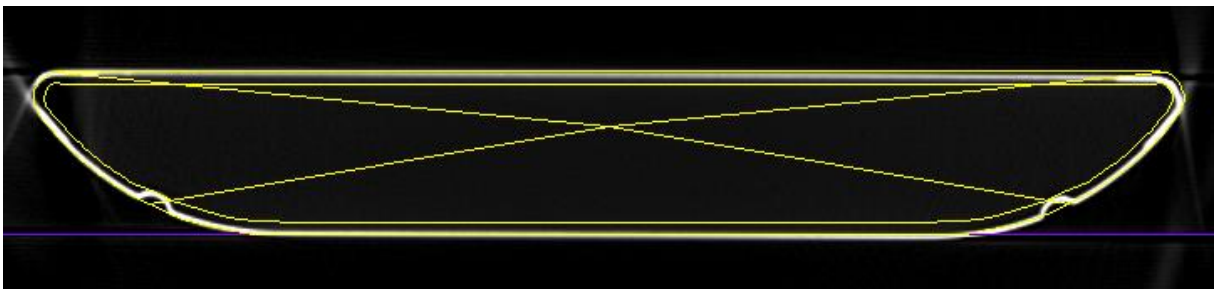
The couch model structures on the CT scan of the Varian IGRT couch between the F1 and F2 notches
